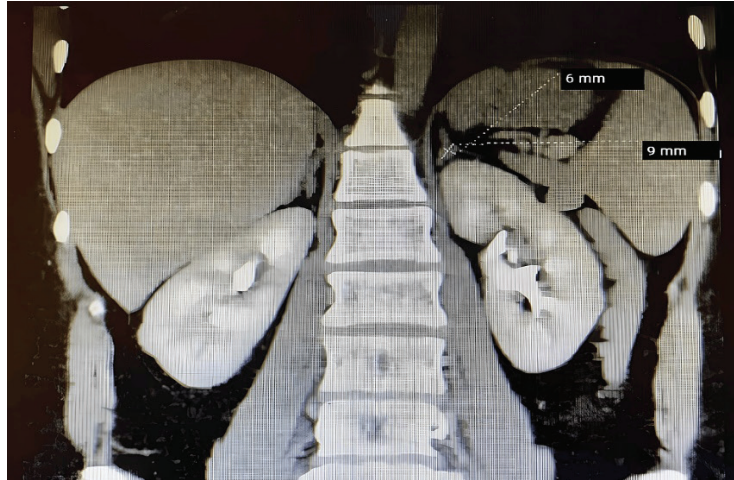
Abdominal CT scan showing a homogeneous lesion, measuring approximately 9mm by 6mm on the left adrenal gland.
